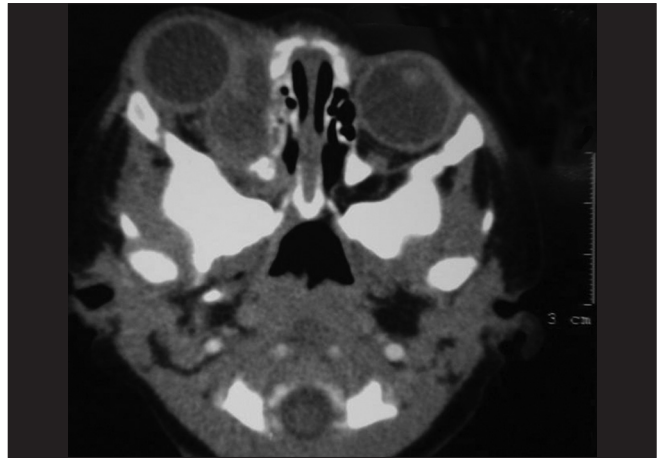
CT scan showed a poorly defined, retrobulbar, slightly hypodense mass extending to the preseptal space, displacing the right medial rectus and reaching up to the superior rectus. Ethmoidal air cells are inflamed
